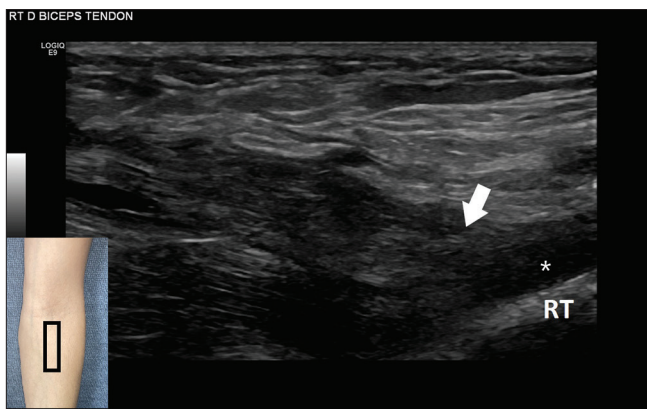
Longitudinal ultrasound image of the corrugated distal biceps tendon at the insertion, demonstrating a rounded tendon stump (arrow) with only fluid and hematoma at the radial tuberosity (asterisk). RT: Radial tuberosity
